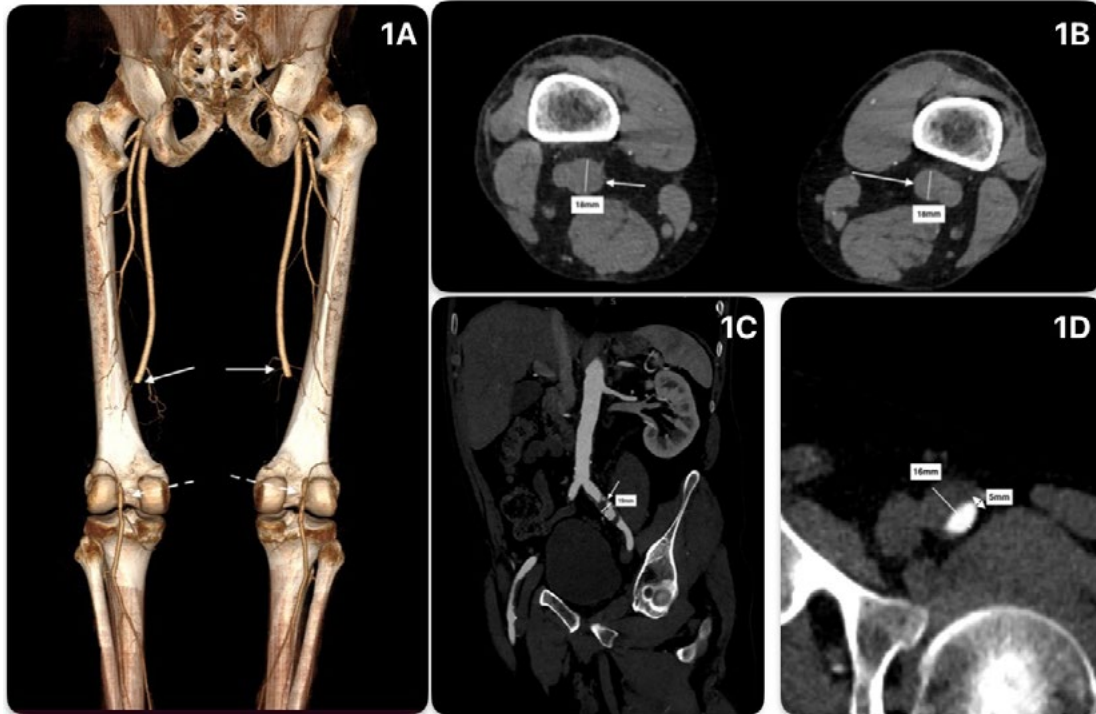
A. 3-dimensional reconstruction of the pre-operative CT scan, in which a posterior view is demonstrated, showing the occluded popliteal arteries (solid white arrows show the proximal and dashed arrows the distal extent of the occlusions) B. Axial CT views at the level of the knee crease showing bilateral 18mm occluded popliteal artery aneurysms C. Coronal view showing the left common iliac artery aneurysm (solid white arrow) with a significant amount of intraluminal thrombus. D. Axial view showing the left common femoral artery aneurysm with a significant amount of intraluminal thrombus, leaving around 30% of residual patent lumen (white arrow).
